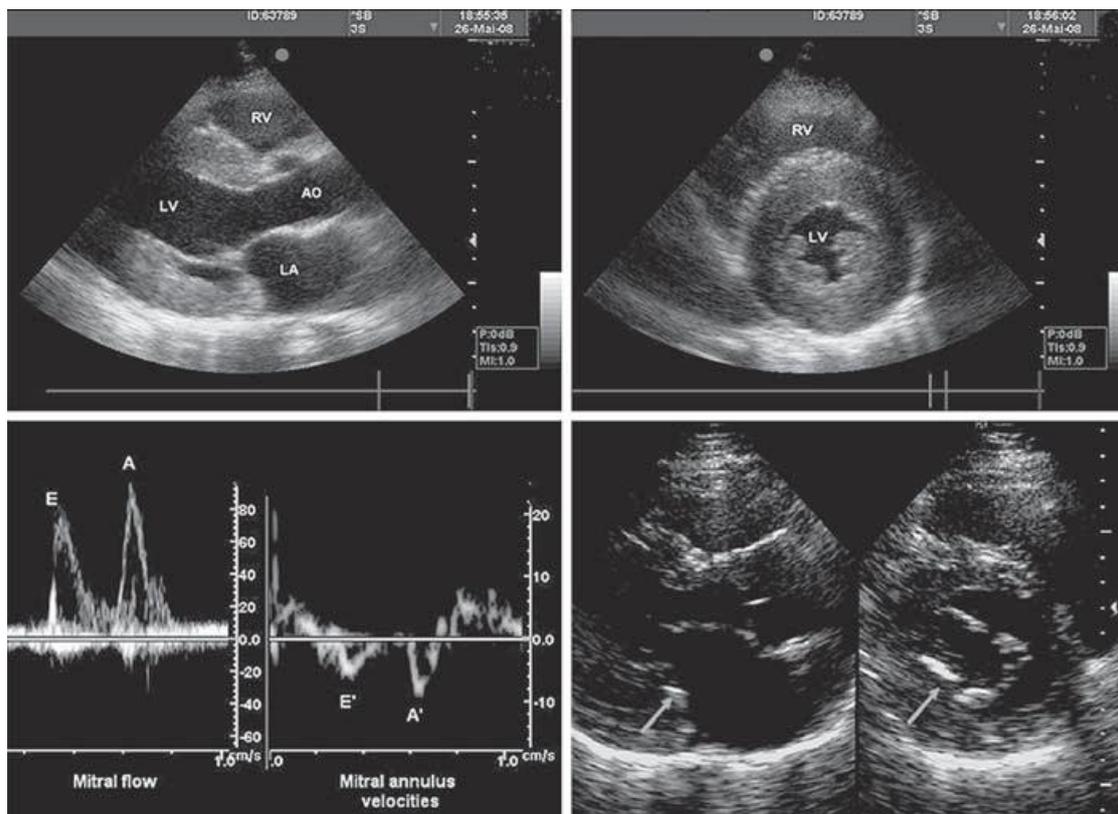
Representative images of echocardiographic findings commonly observed.
